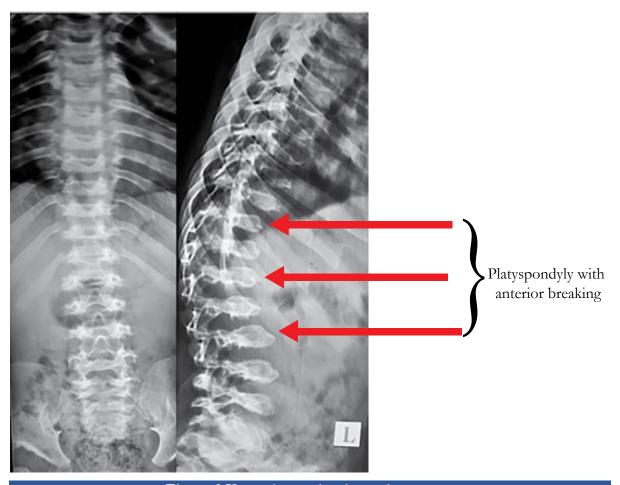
X-ray thoracolumbar spine
